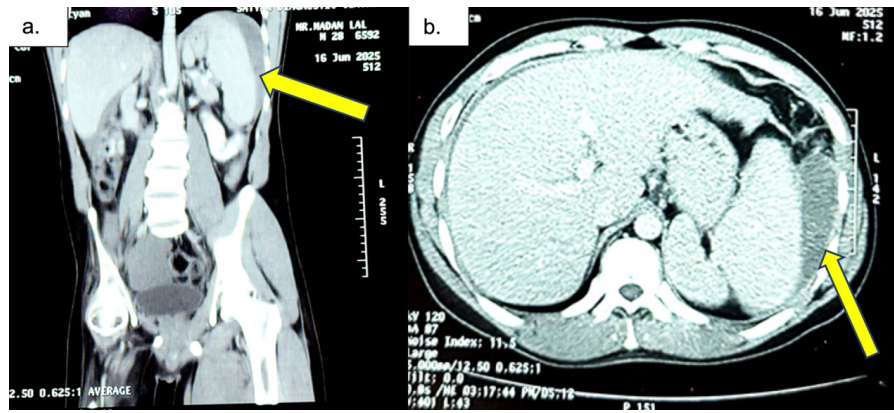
a. Coronal view and b. sagittal view of CT images showing perisplenic collection (Arrow) with enlarged spleen
